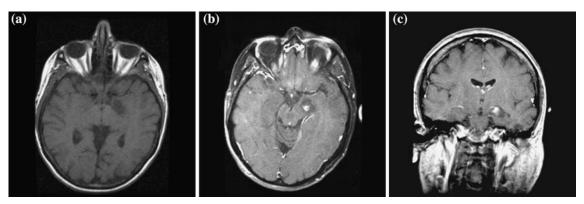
(a) Axial T1-weighted magnetic resonance image demonstrating a left mesial low-attenuated lesion. (b) Axial T1-weighted magnetic resonance image after gadolinium administration. (c) Coronal T1-weighted magnetic resonance image after gadolinium administration. In these images, which were obtained 15 years after those in Figure 1, the T1-weighted hypointense lesion measures 2.3×2.2×2.2 cm. A new enhancing focus at the center of the lesions measures 4×8 mm and suggested progression of the disease.
